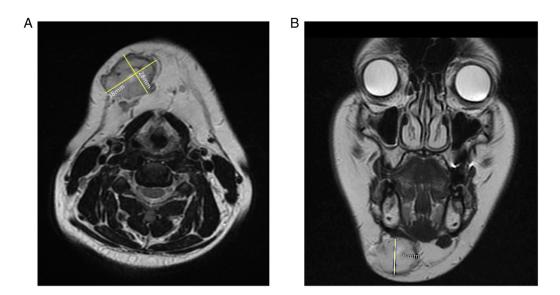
Last head and neck MRI before surgery showing T2 weighted images. (A) Axial view showing a hyperintense (relative to muscle) well circumscribed mass measuring 38x28x23 mm. (B) Coronal view.
